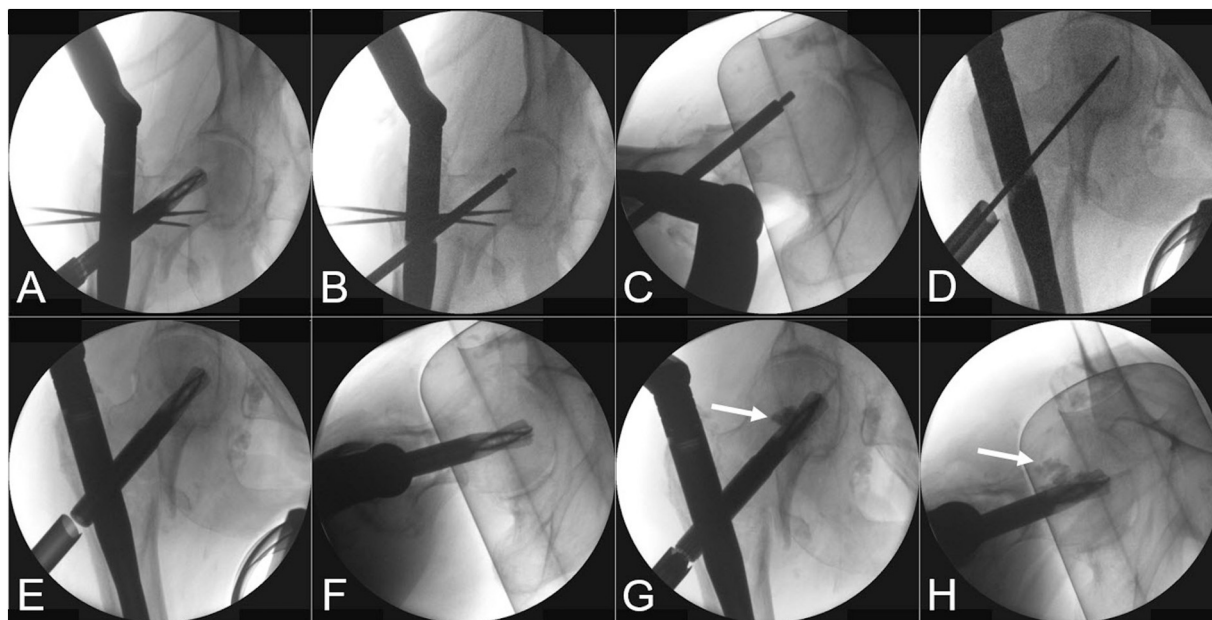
Radiographs showing (A) Prophylactic fixation and helical blade removal. (B; C) Insertion of the medullary cement plug. (D) Positioning of guide wire in center-center position. (E; F) Replantation of the helical blade in center-center position. (G; H) Cement augmentation and defect filling by the cement augmentation (arrow) is visible.
